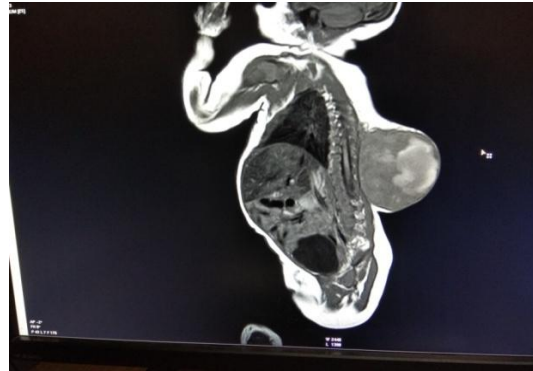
MRI showing a paravertebral lesion non communicating with spinal cord
